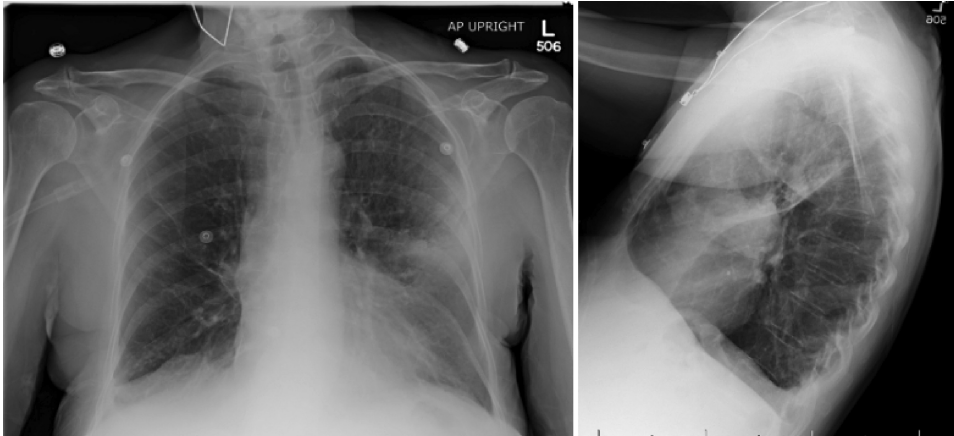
Anteroposterior and lateral films of the patient's chest radiography.
